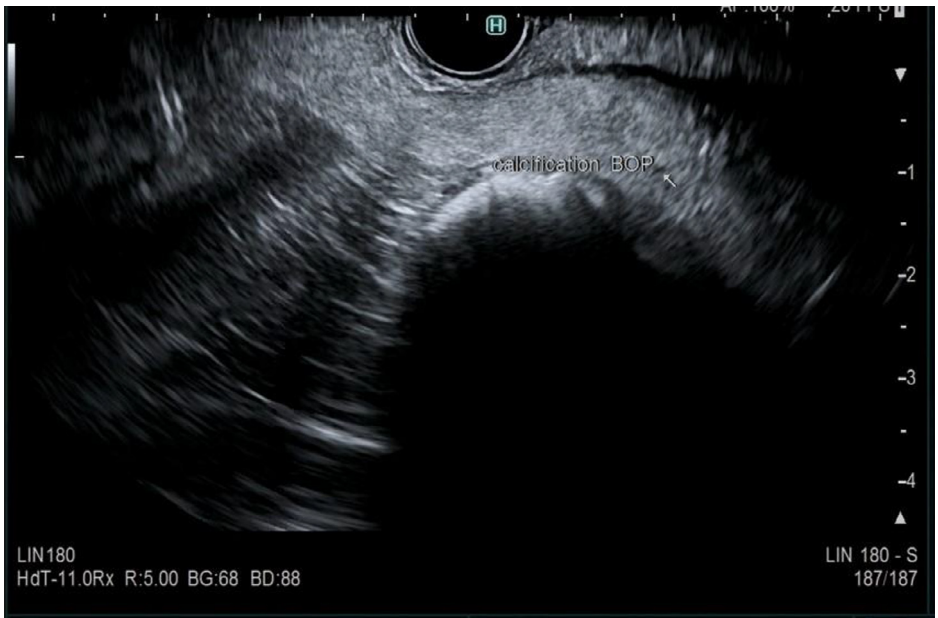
Endoscopic ultrasound showing calcification in the body of pancreas
